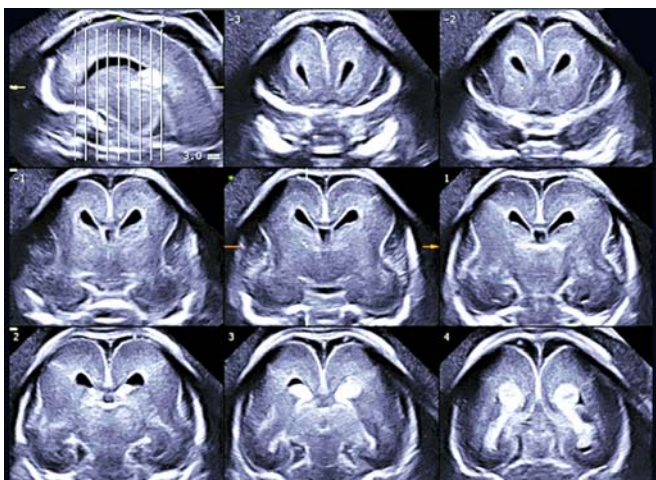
Tomographic ultrasound imaging of normal brain in coronal cutting section at 20 weeks
